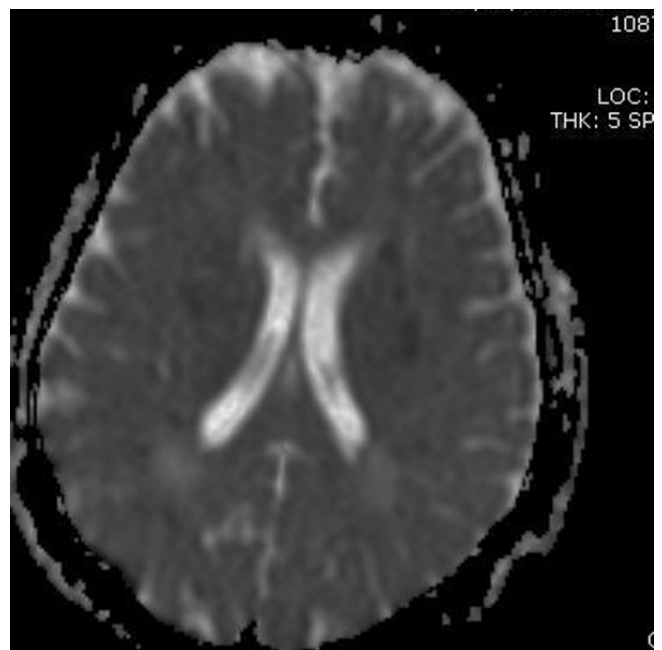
Diffusion-weighted magnetic resonance imaging.
